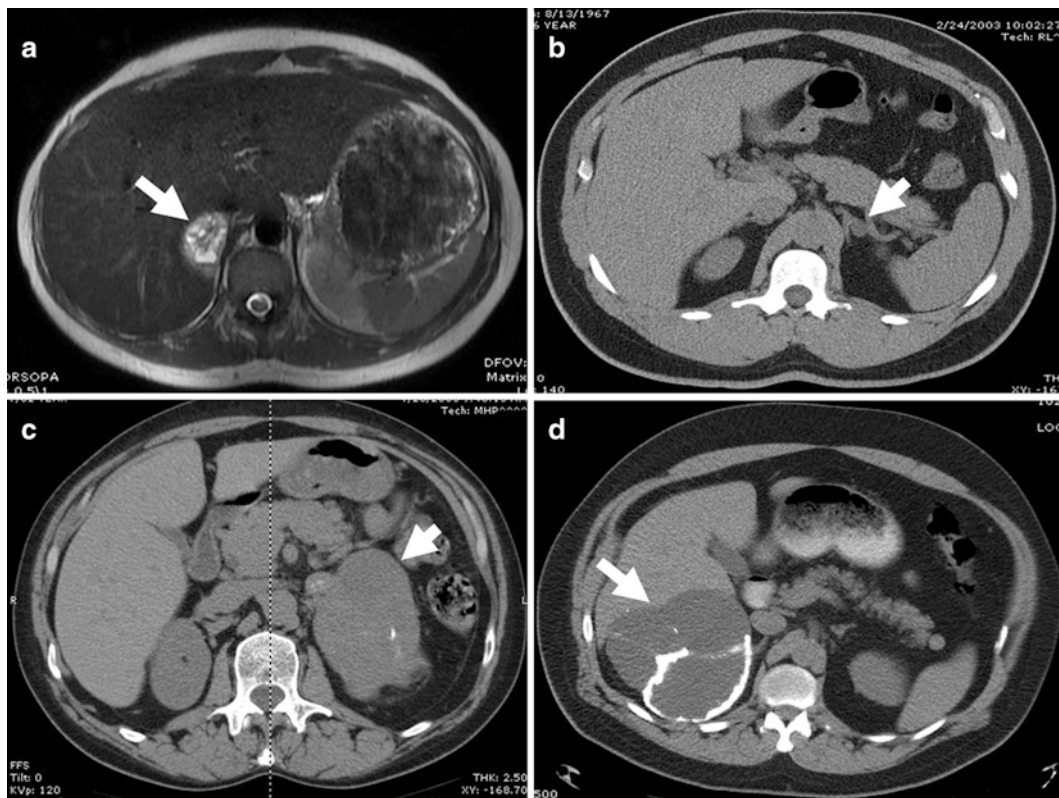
Representative image characteristics of older patients with adrenal tumors. (a) A 68-year-old female with a 4.9-cm right pheochromocytoma (arrow). T2-weighted image on MRI displays a partly cystic lesion markedly hyperintense compared to the liver. (b) A 72-year-old male with a 1.2-cm left adrenal incidentaloma (arrow). The unenhanced CT scan shows a small, round, homogeneous mass with low attenuation. Biochemical evaluation was consistent with primary hyperaldosteronism, and pathology revealed an adrenocortical
